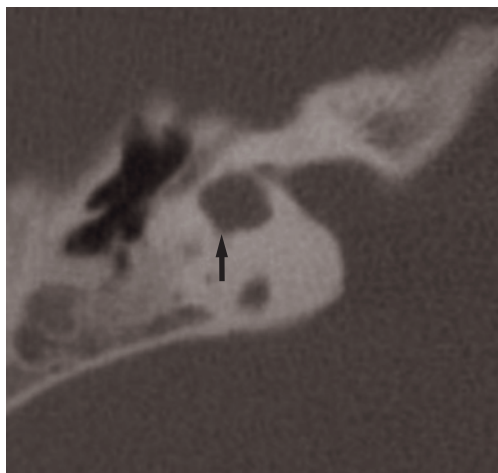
Axial CT scan. Inner ear malformation: the cochlea and vestibule form a 'common cavity' (arrow). Patient with BOR syndrome.
